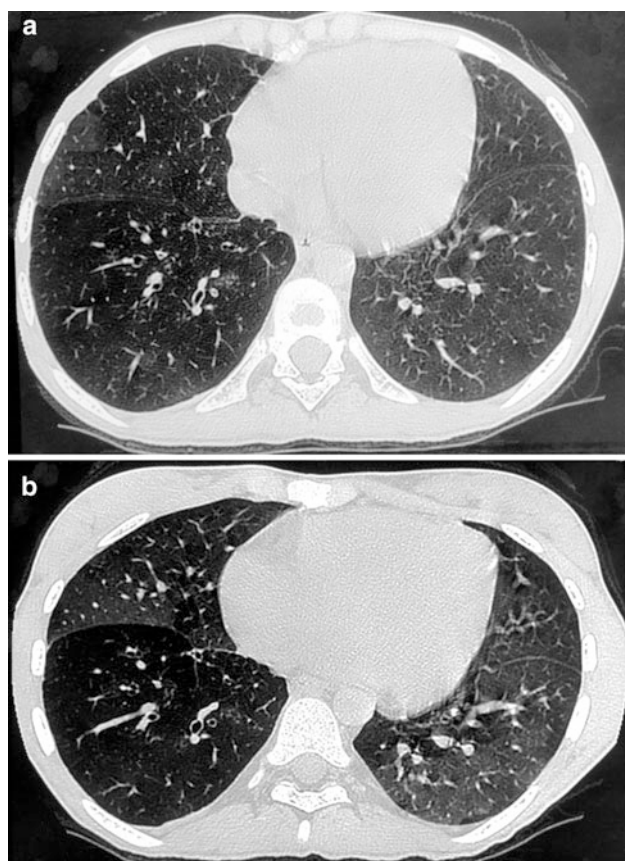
Inspiratory (a) and expiratory (b) HRCT scans in a 10-year-old boy with postinfectious bronchiolitis obliterans (mycoplasma infection). CT shows bronchiectasis in the lingula and in the left lower lobe. It also demonstrates bilateral mosaic perfusion pattern with air trapping
